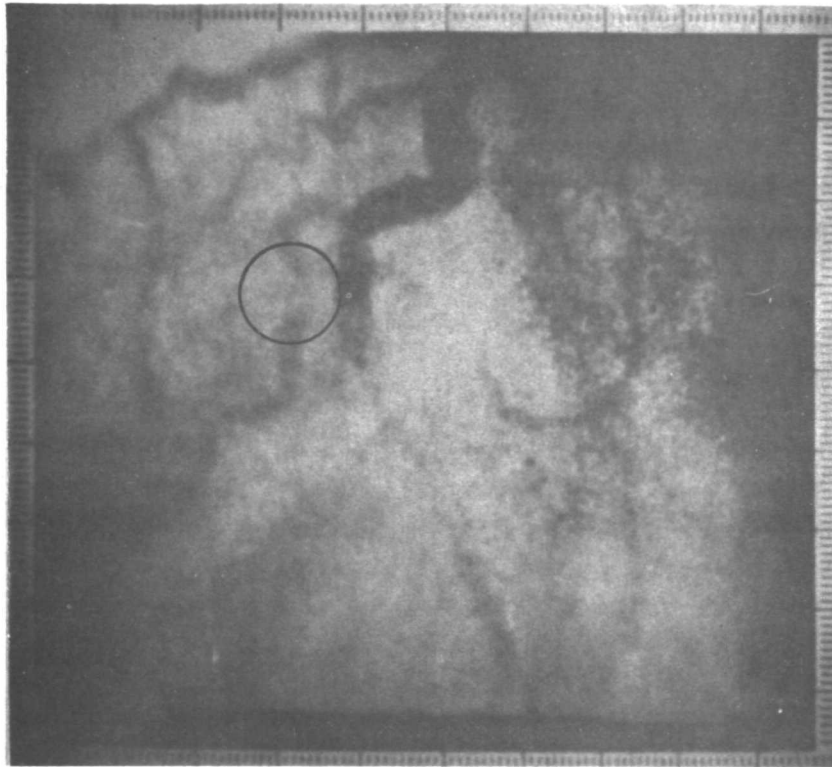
X-Ray of human heart enhanced by computer techniques.
